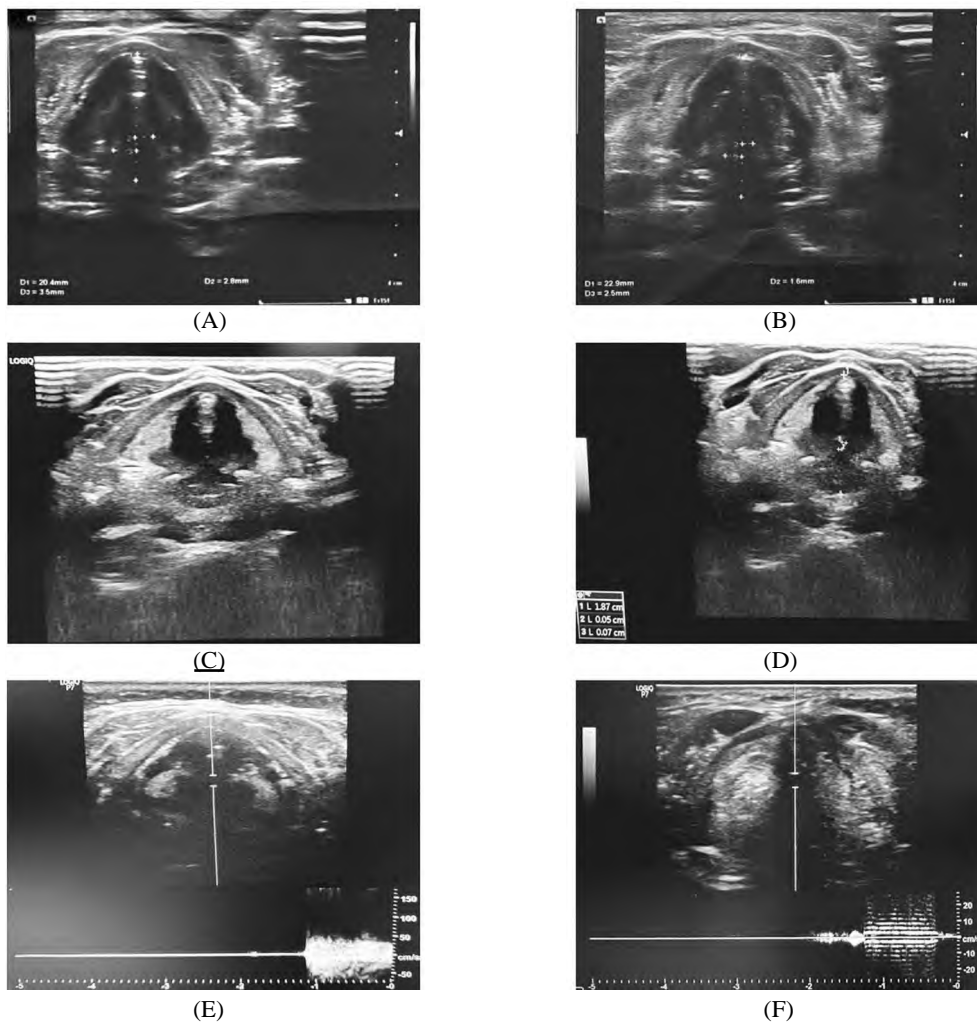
A 38 years old female patient, presented with Hashimoto thyroiditis with large thyroid nodule (TIRAD 3), partial thyroidectomy was done and she experienced hoarseness of voice 2 weeks later. Laryngeal ultrasonography was done and positive result was reported of immobile bilateral VFs with distance 0.5 mm from midline at both valsalva and active inspiration. Laryngoscopy was done and the result was confirming bilateral VFs paralysis. Immediate tracheostomy was done and she referred to ENT clinic for treatment and good observation. VFDV before thyroidectomy was 49 cm/s and it was 7 cm/s after thyroidectomy. The normal VFs movement in a female has Hashimoto thyroiditis with large thyroid nodules (TIRAD 3) before thyroidectomy during valsalva maneuver and active inspiration, (A) Showing abduction of both VFs normally during active inspiration, the right VF abduction by 3.5 mm from midline and the left VF by 2.9 mm. (B) Showing adduction of both VFs normally during valsalva maneuver, the right VF adduction by 1.6 mm from midline and the left VF by 2 mm. The VFs movement in a bilateral VFs paralysis female after thyroidectomy during valsalva maneuver and active inspiration, (C and D) Showing fixed bilateral VFs with 0.5 mm distance from midline during both valsalva maneuver and active inspiration. (E) Showing VFDV before thyroidectomy measuring 49 cm/s. (F) Showing VFDV after thyroidectomy measuring 7 cm/s. Laryngoscopy confirmed bilateral vocal cords paralysis.
